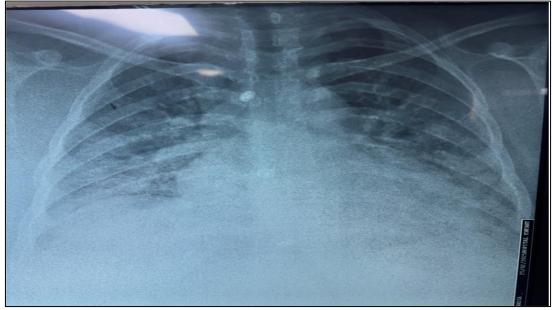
Chest X-Ray Showing Cardiomegaly and Bilateral Pulmonary Edema
